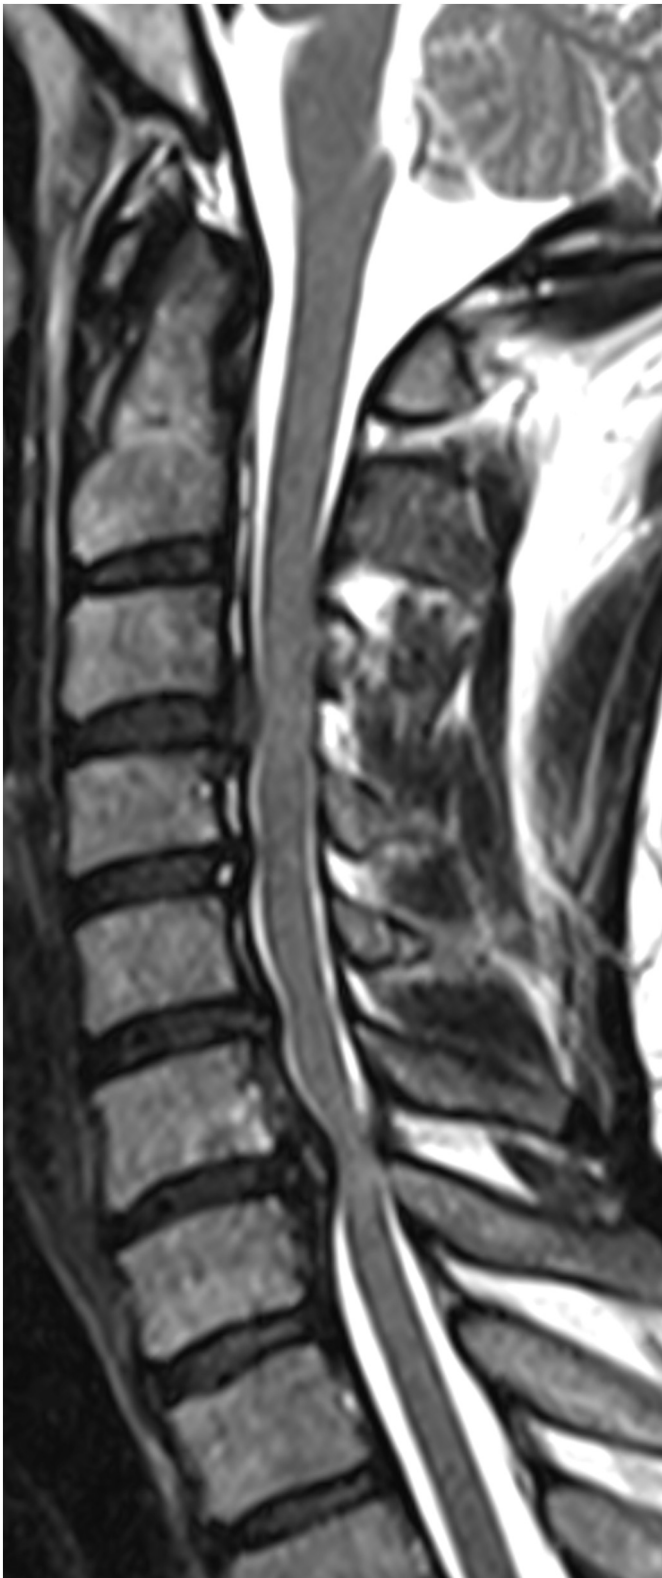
Preoperative MRI of the cervical spine, T2 sagittal sequence demonstrating intervertebral disc herniation and spinal gliosis at the C6–C7 junction.
